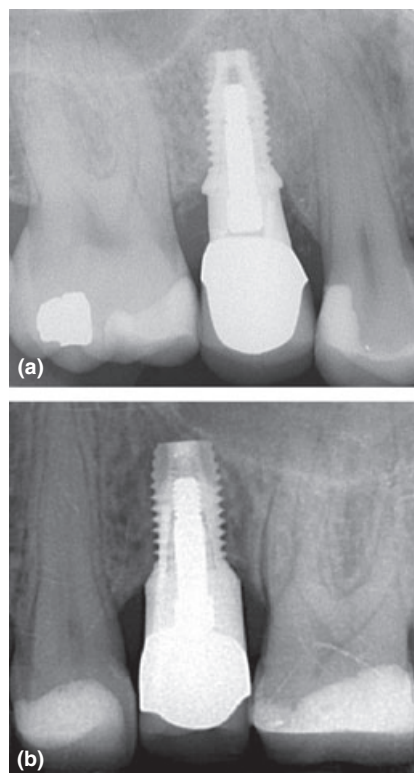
(a) A radiograph of a test implant (Osseotite Certain Prevail, Biomet 3i). (b) A radiograph of a control implant (Osseotite XP Certain, Biomet 3i).
